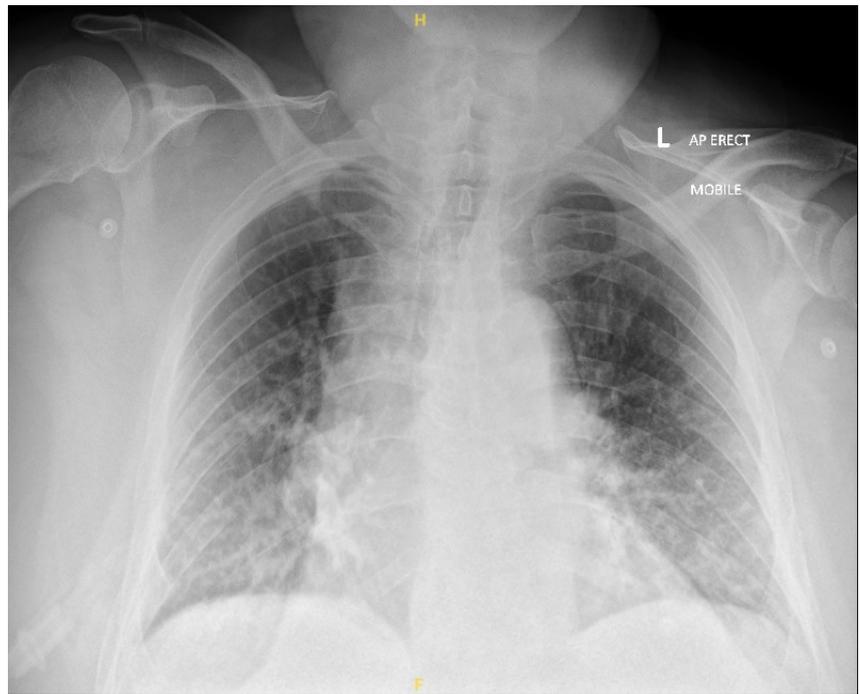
Chest X-ray demonstrating widespread opacities bilaterally, more predominant in the middle/lower zones.
